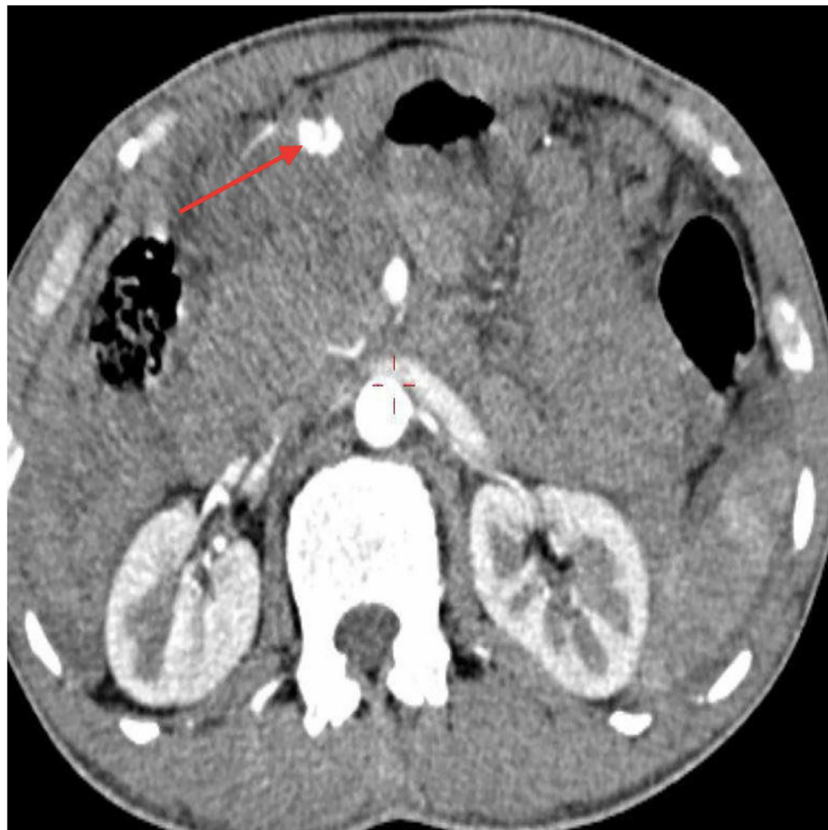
Contrast-enhanced CT (arterial phase axial image at the level of renal hilum) showing the contrast-filled focal outpouching of the right gastroduodenal artery (red arrow).
